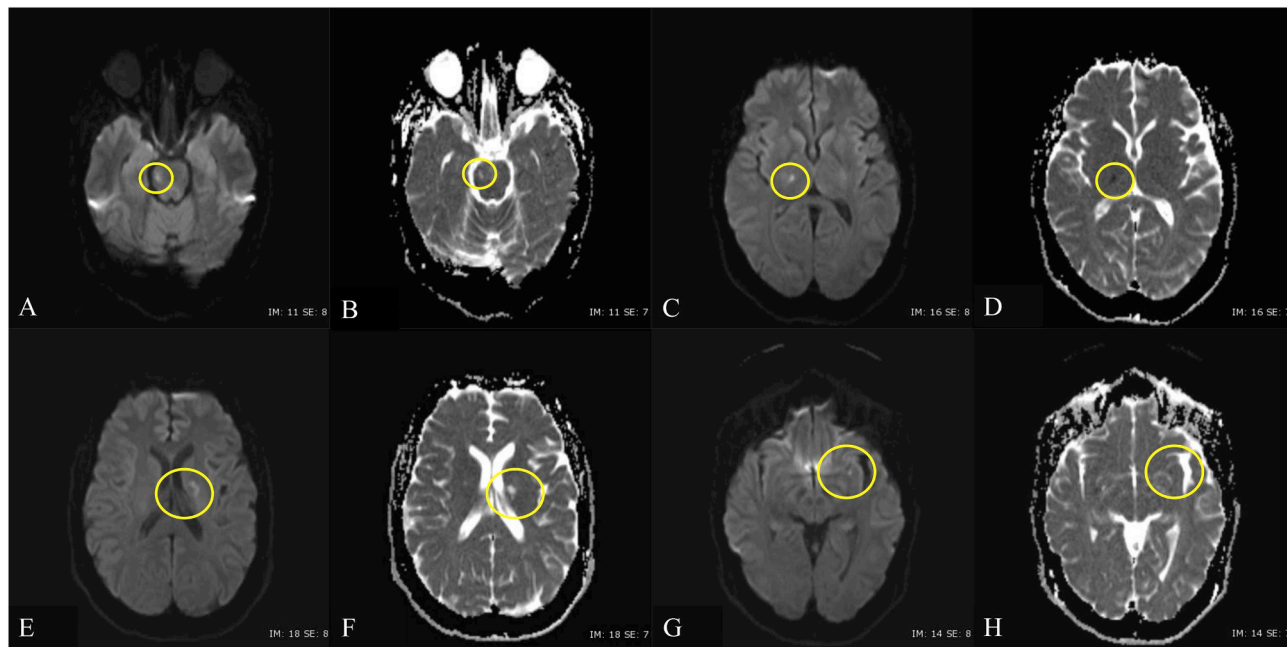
Magnetic resonance imaging (MRI) - initial (A–D) and follow up (E–H). A focal, chronic infarct in the right lateral aspect of the upper pons appears hyperintense on both diffusion-weighted imaging (DWI) (A) and apparent diffusion coefficient (ADC) map (B). An acute infarction in the right thalamus is demonstrated by the combination of a hyperintense signal on DWI (C) and marked hypointense signal on ADC (D). Follow up imaging shows interval development of two new infarcts (E–H). A chronic infarct is seen within the genu and anterior limb of the left internal capsule (E–F). It appears hyperintense on both DWI (E) and ADC map (F). A more acute punctate infarct is seen within the left anterior subinsular region (G–H). The combination of hyperintense signal on DWI (G) and hypointense signal on ADC (H) indicates an acute process.
